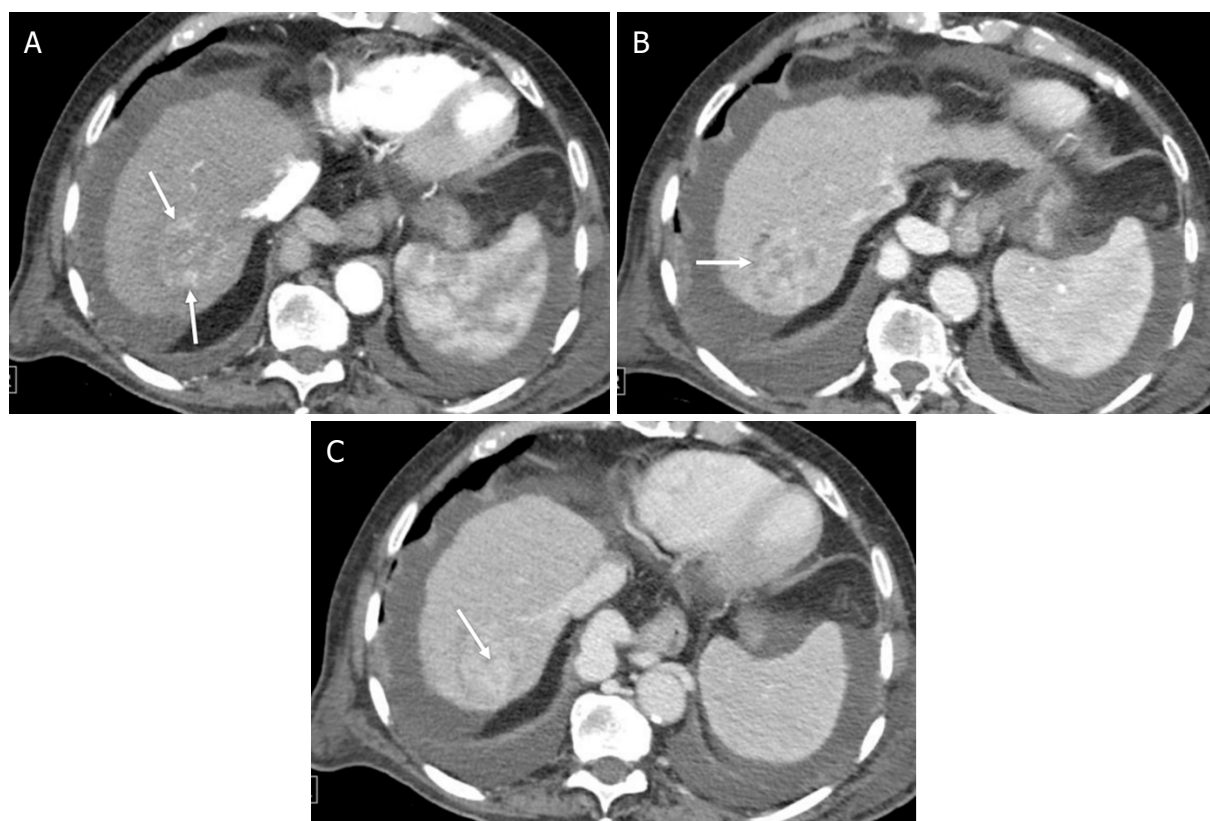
LR-M (Probably or definitely malignant, not hepatocellular carcinoma specific). Axial Computed Tomography in an 80-year-old man with hepatitis C cirrhosis. Arterial phase (A); portal venous phase (B); and delayed phases (C) demonstrate a 40-mm observation with rim arterial phase hyperenhancement [arrows (A)], peripheral washout appearance [arrow (B)], and delayed central enhancement [arrow (C)] observation. Subsequent biopsy confirmed an intrahepatic cholangiocarcinoma
